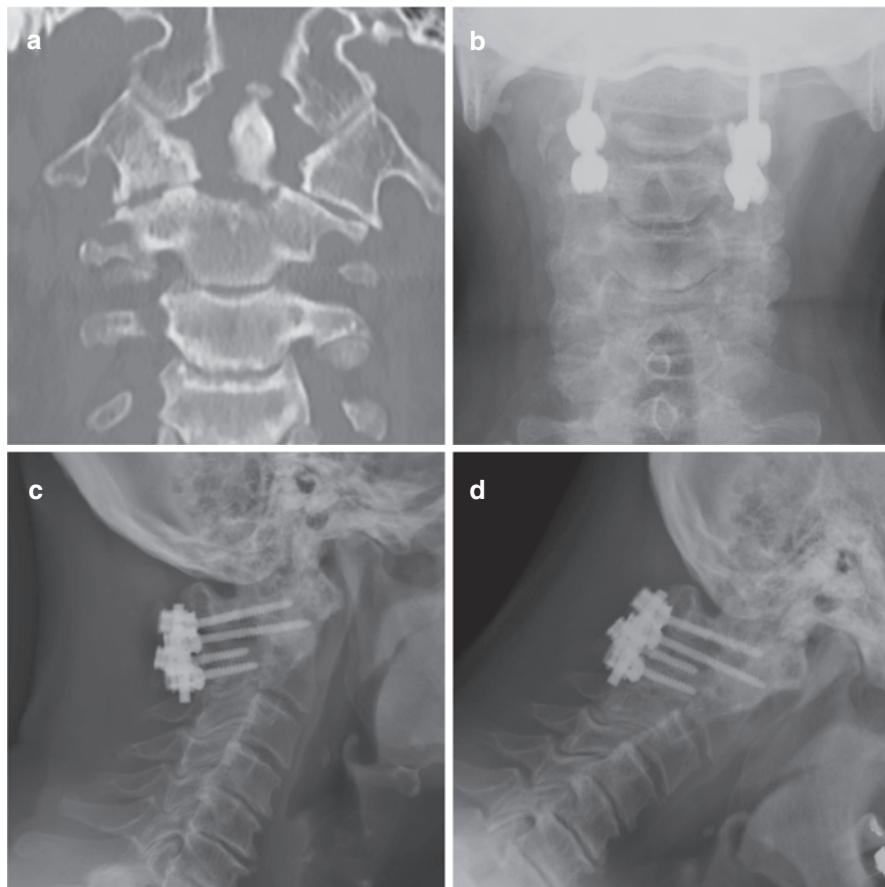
(a) Coronal cervical spine CT showing a type II odontoid fracture. (b) Anteroposterior postoperative cervical spine X-ray showing a posterior construct was performed with C1 lateral mass and C2 pars screw. (c, d) Lateral X-rays of the C1–2 fusion construct showing no displacement of the dens and a solid fusion on flexion X-rays (d). These images were obtained 2 years following fusion
